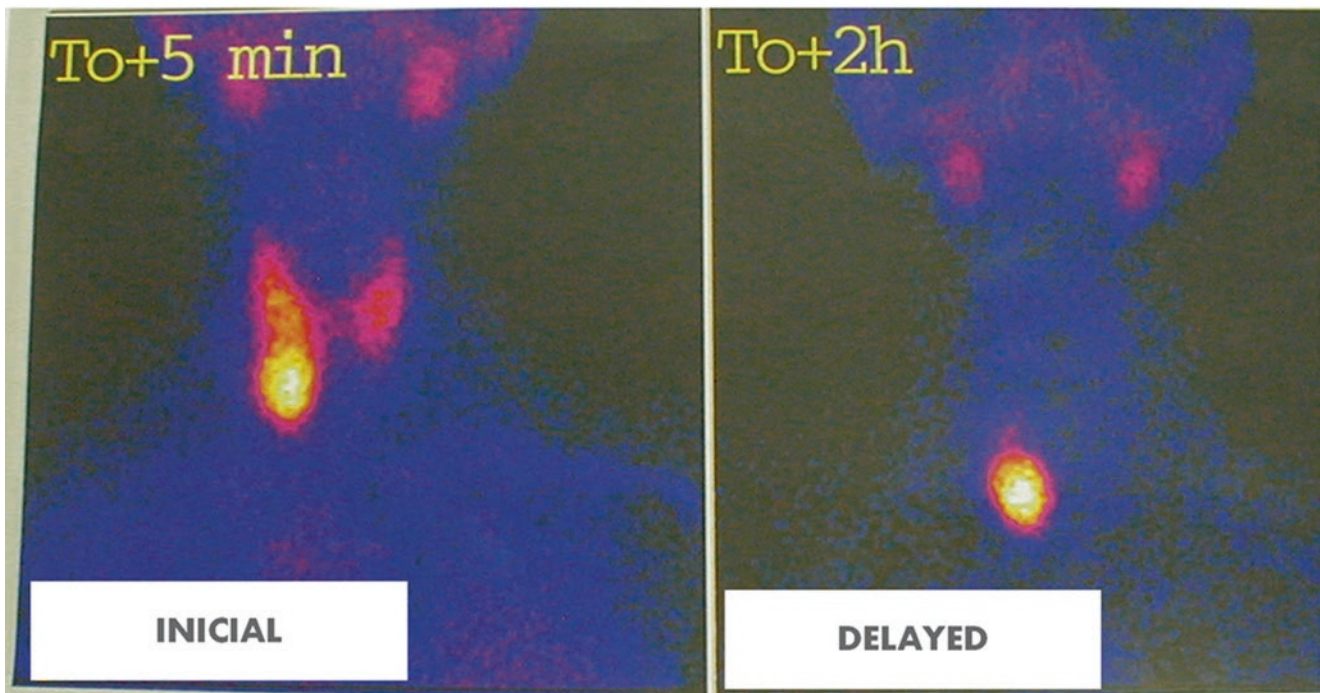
^{99m}Tc -Sestamibi scintigraphy showing a large parathyroid adenoma
